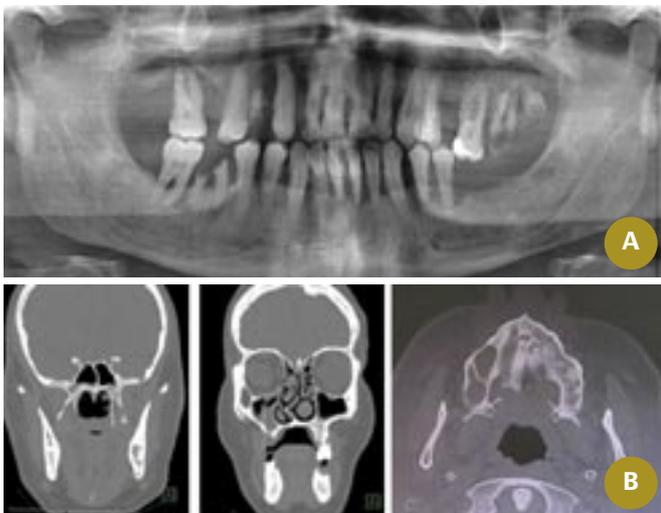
A: Pre-operative orthopantomogram showed bone destruction on the upper right side and a remaining root right first premolar and carious right lateral incisor; B: Cone beam computed tomography showed an ill-defined soft tissue mass measuring 19x20x17mm on the palatine process of the right maxillary and alveolar bone with underlying bone erosion, mucosal thickening of the maxillary, ethmoidal, frontal and sphenoid sinuses, and hypertrophied inferior conchae. The nasal septum deviated to the right.
